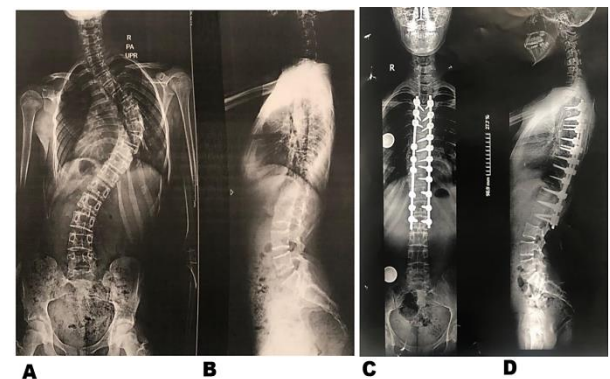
A 12-year-old girl with Lenke type 1 curve undergoing T4-L2 posterior spinal fusion; A, B preoperative standing full length posteroanterior and lateral radiographs; C, D after deformity correction and instrumentation
